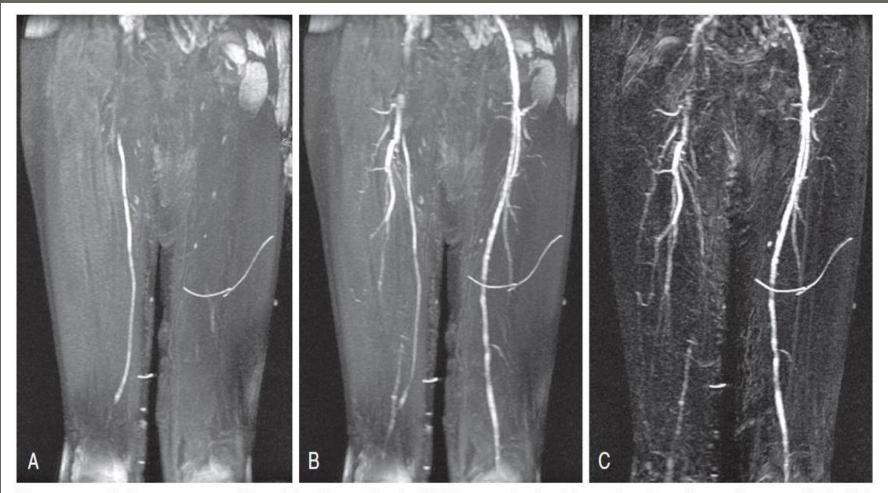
A, Precontrast coronal T1-weighted image showing high intravascular signal from a thrombosed femoral bypass graft. The high signal is from methemoglobin in the thrombus. B, Coronal 3D MR angiogram showing that the signal from the thrombus is as high as signal in the contralateral superficial femoral artery. There are signal voids at the origin and touchdown of the graft, suggesting stenosis, when in fact the entire graft is occluded. C, Subtraction image of the arterial-phase image minus the precontrast image showing only the contrast-enhancing arteries.
